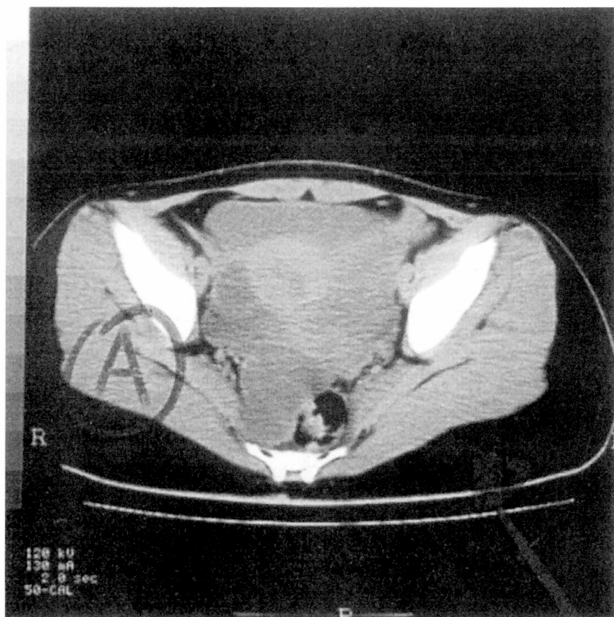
Contrast-enhanced CT of the pelvis shows a large multilocular predominantly cystic mass with a few enhancing solid elements.
